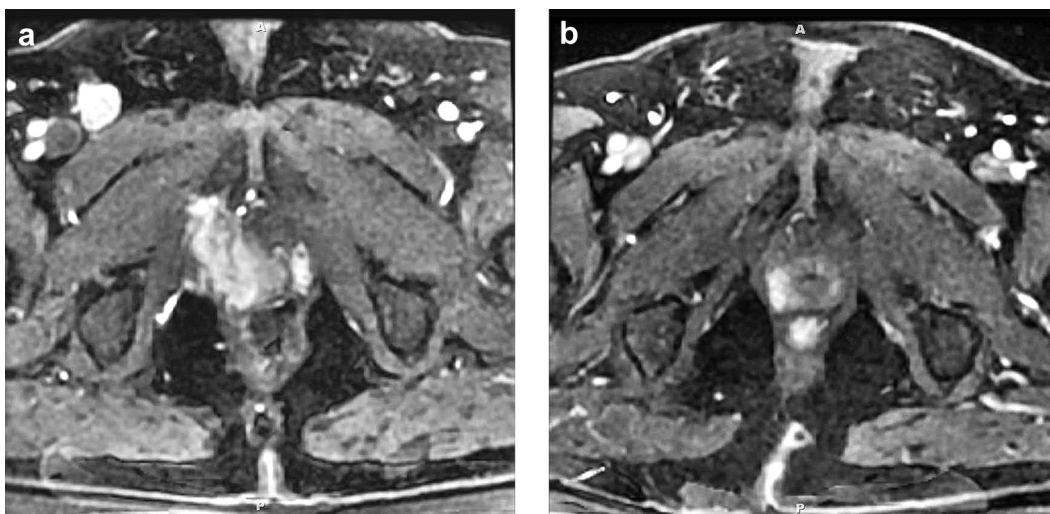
Dynamic contrast enhanced (DCE) axial MRI images depicting disease infiltrating pelvic muscles prior to ADT (a) and resolution post-ADT (b).
